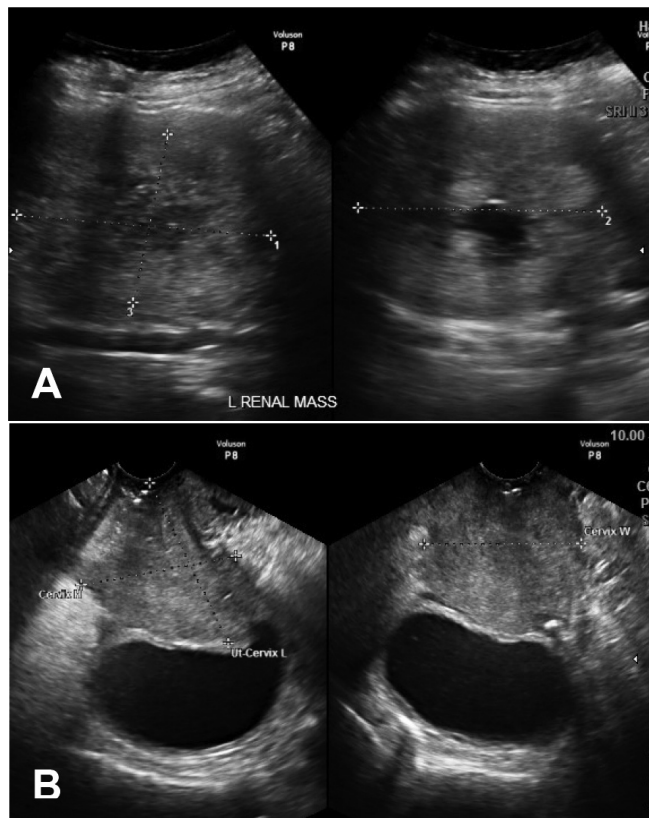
A. Transvaginal ultrasound showing the cervical mass. B. Transabdominal ultrasound showing the left renal mass.
